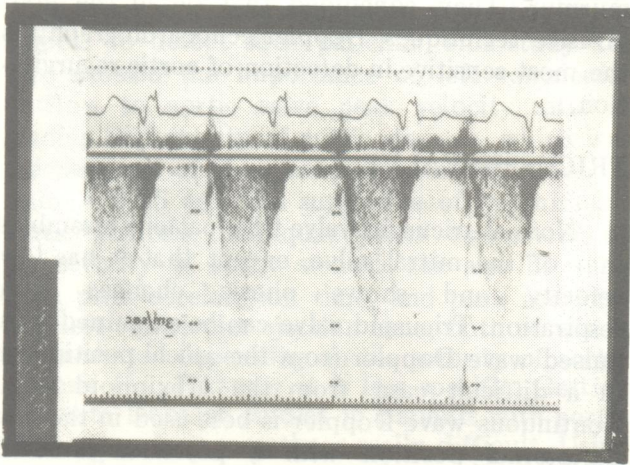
A. doppler recording across the tricuspid valve (apical view) in a patient with tricuspid regurgitation.
